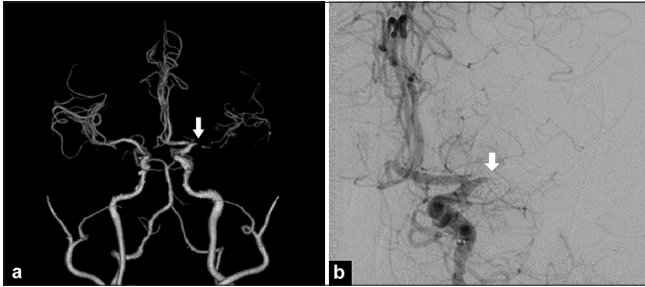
(a) Head and neck computed tomography angiography showing occlusion of the M1 segment of the left middle cerebral artery (MCA) (white arrow). (b) Digital subtraction angiography confirmed the MCA M1 segment occlusion (white arrow) as the culprit vessel.
